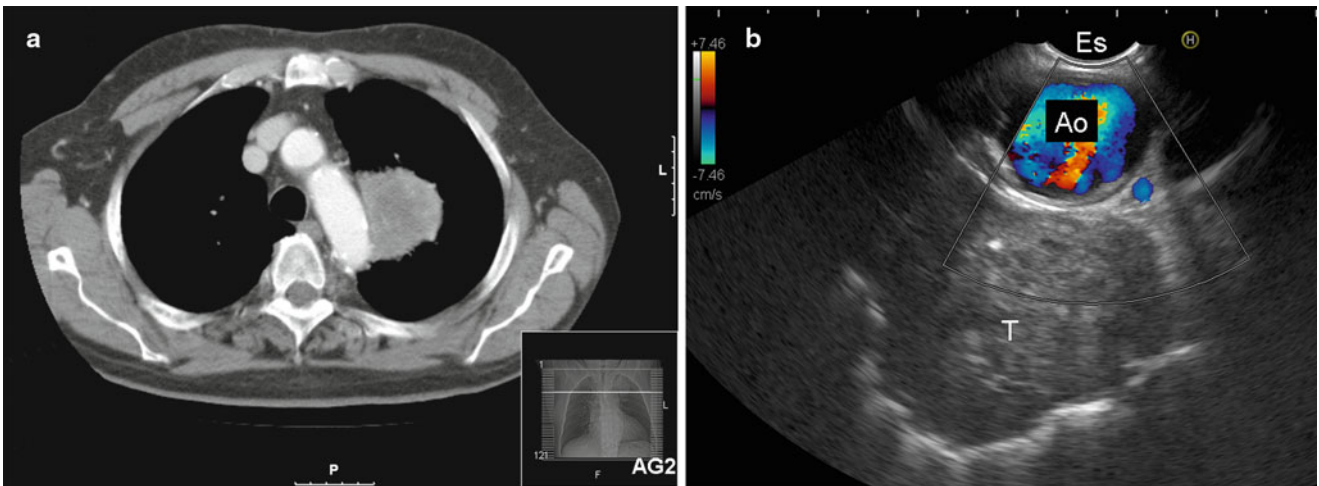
(a) CT scan of the chest demonstrating a tumor of the left upper lobe located adjacent to the aorta. (b) Corresponding EUS image showing the left upper lobe tumor (*T*). The aorta (*AO*) functions as an ultrasound window. There are no signs of aortic invasion. *ES* esophagus
